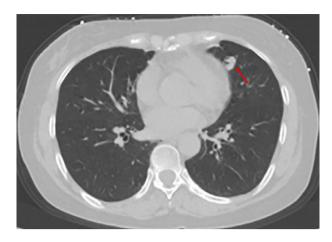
Contrast-enhanced computed tomography indicated an irregular solid nodule with a maximum diameter of 1.2 cm in the lingual segment of the left upper pulmonary lobe.
